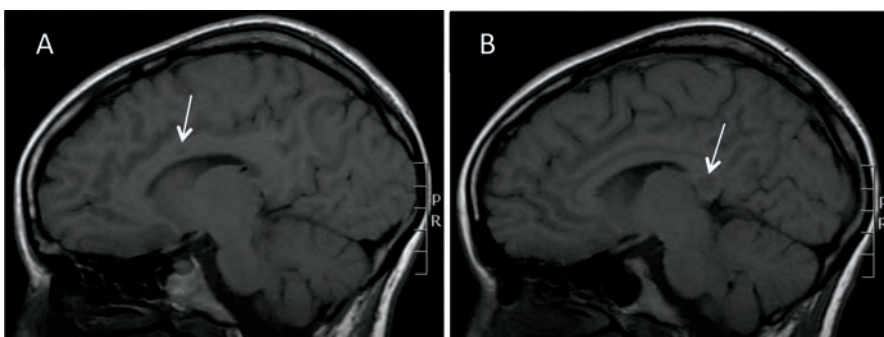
Sagittal T1 MRI sequences (A) and (B) showing corpus callosal 'punched out' holes (arrows). These evolve from 'snowball' lesions and so occur later in the course of the disease.
